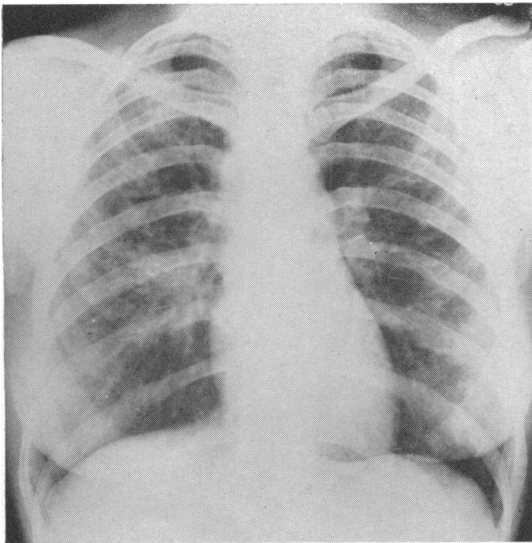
Case 2. Radiograph of chest, May, 1958, showing spread of mottled shadowing in both lungs during antituberculosis chemotherapy.
